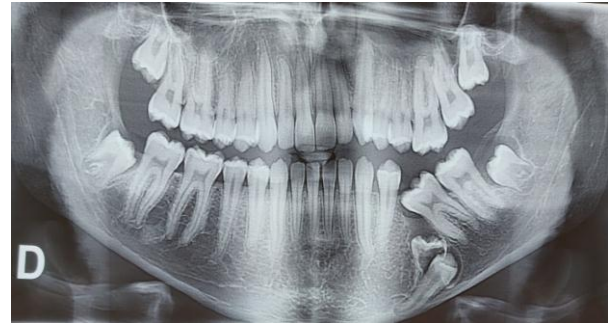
Orthopantomograph showing submerged mandibular primary left second molar (75) in alveolar bone with root resorption and also deep impaction of the second premolar (35)
